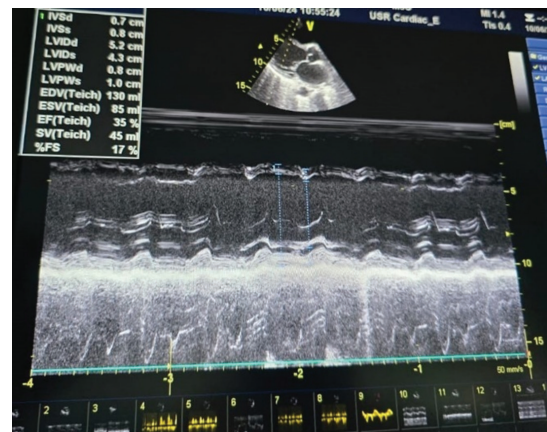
Bedside echocardiography showing reduced LVEF
